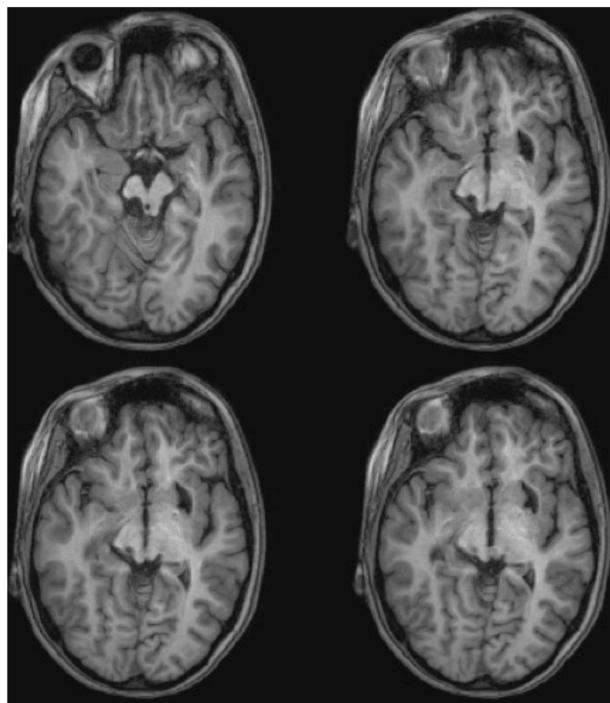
High resolution (0.7 mm³) T1-weighted MRI of patient ML.
